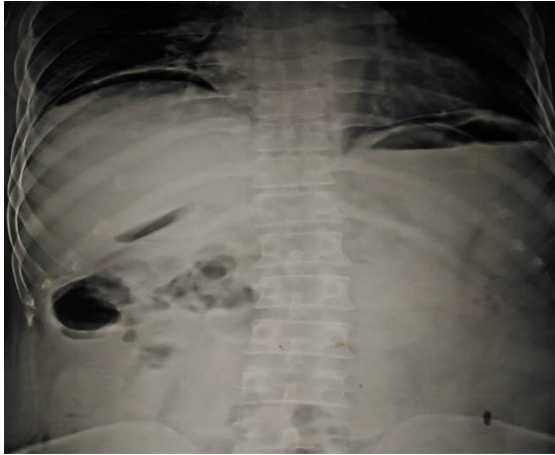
Erect X-ray abdomen showing free gas under right dome of diaphragm.
